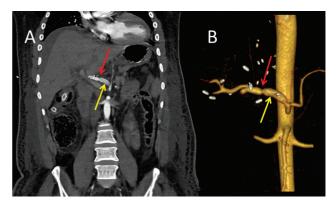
A 44-year-old male patient post deceased donor liver transplantation (DDLT) - postoperative day (POD) 5. Coronal contrastenhanced computed tomography (CECT) image (A) shows linear filling defect (yellow arrow) in the proximal hepatic artery with luminal irregularity s/o dissection in the recipient common hepatic artery and focal narrowing at the anastomotic site (red arrow). Virtual reconstructed image (B) demonstrates the same findings (yellow and red arrows).
